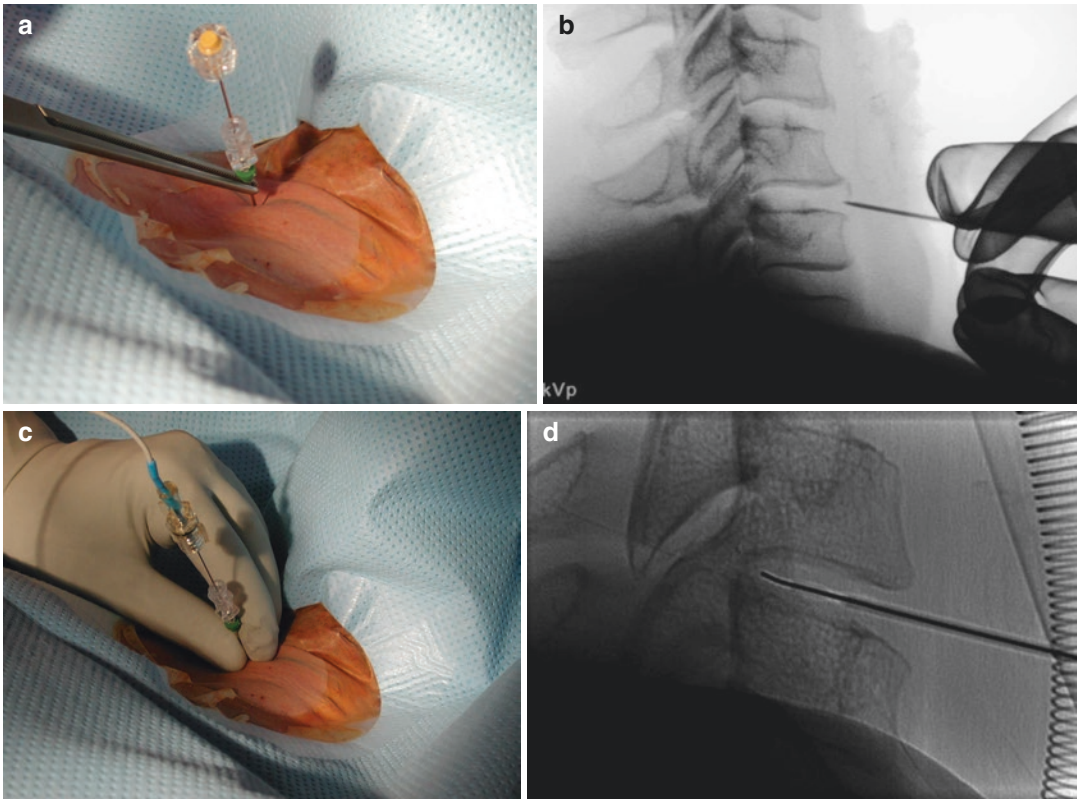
(a) The 19-gauge cannula with an internal mandrel is positioned against the anterior surface of the annulus fibrosus. The cannula is held by a surgical forceps to minimize X-ray exposure of the surgeon's hand. (b)
